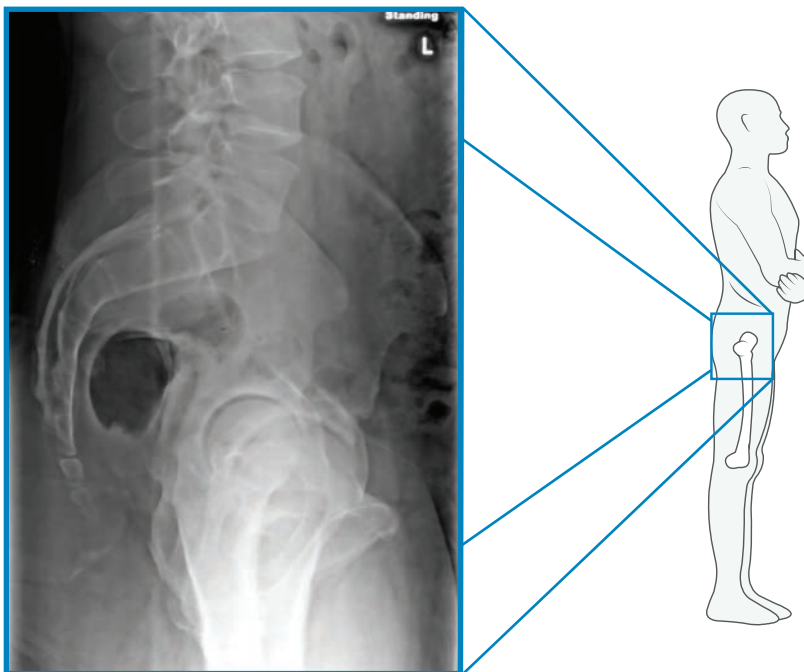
Preoperative Lateral Standing X-ray
